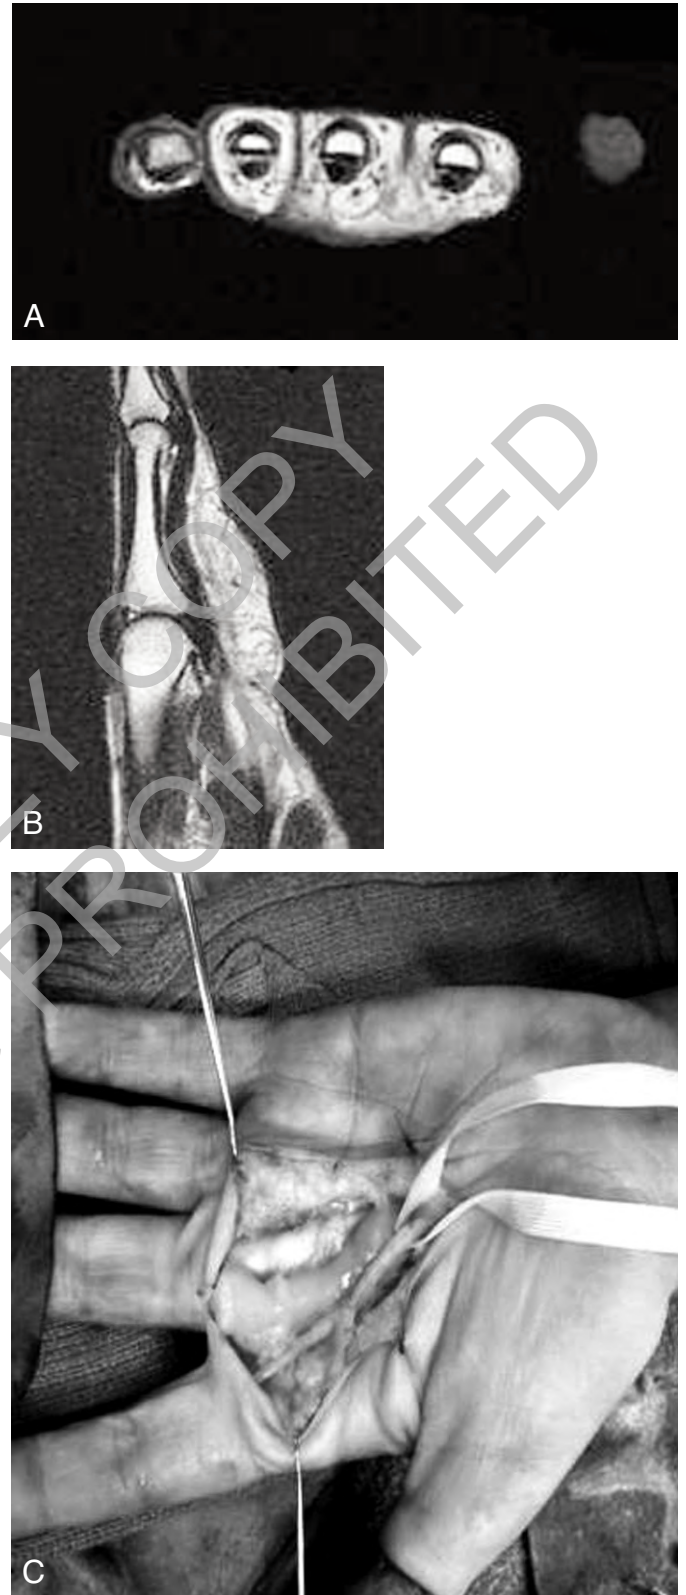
Left hand FLH. MRI scan of the left hand showing a coaxial-cable-like appearance typical of a FLH affecting the second common digital nerve, transvers plane (A). MRI scan of the left hand showing a spaghetti-like appearance typical of a FLH affecting the second common digital nerve, sagittal plane (B). Intraoperative photograph of the left hand showing the FLH dissected from the second common digital nerve and other deep palmar structures (C).
